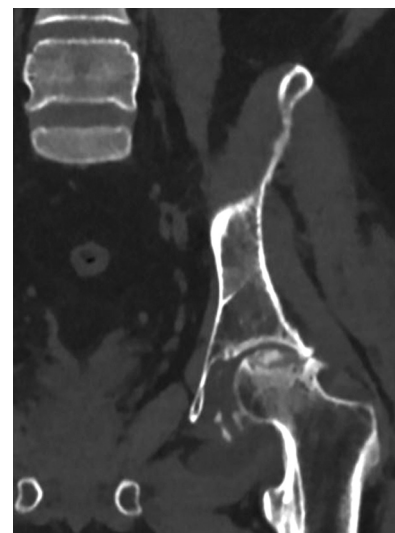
Left hip CT scan of patient SH. at admission
